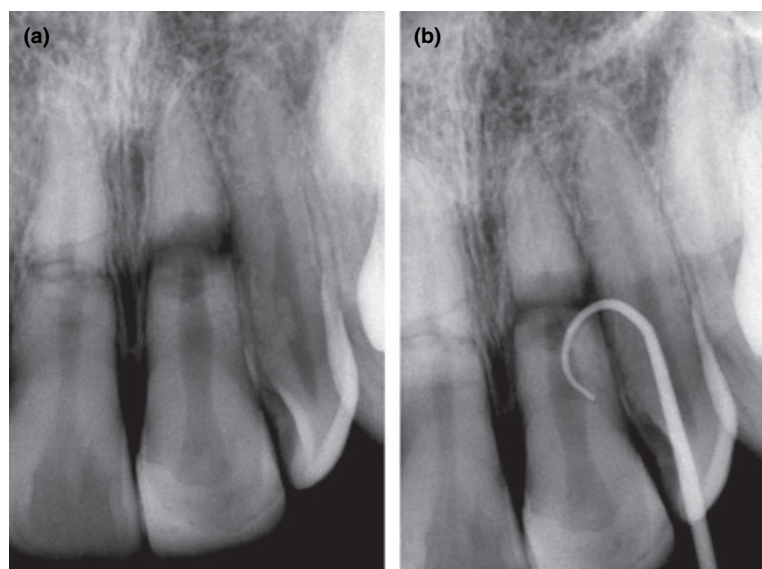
(a) Preoperative periapical radiography 4 months after the trauma, showing horizontal root fracture in both maxillary incisors. (b) Gutta-percha cone tracing the sinus tract to the middle third of tooth 21.
